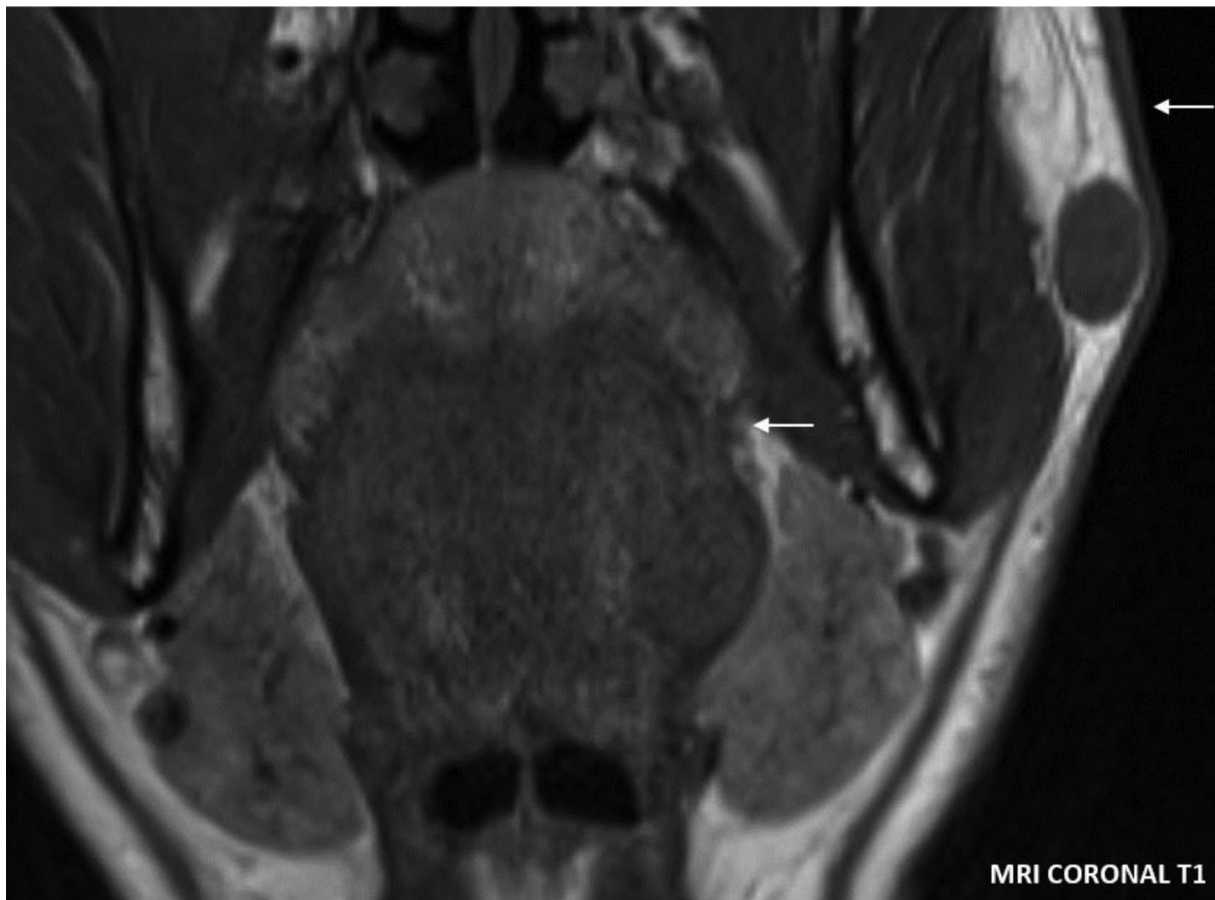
MRI: Coronal T1 sequence. A well-defined T1 hypointense subcutaneous lesion in the left parotid region, and another well-defined T1 hypointense ovoid lesion in the left tongue.
